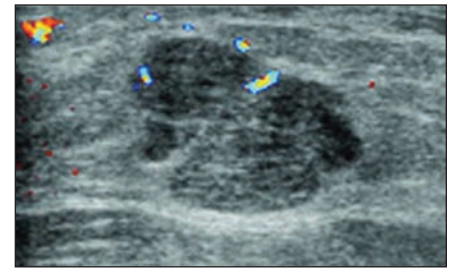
13-year-old girl with palpable mass in right breast. Sonogram shows 3-cm well-circumscribed heterogeneously hypoechoic mass with more than three macrolobulations, minimal vascularity, and increased through-transmission. Excisional biopsy revealed benign phyllodes tumor.
